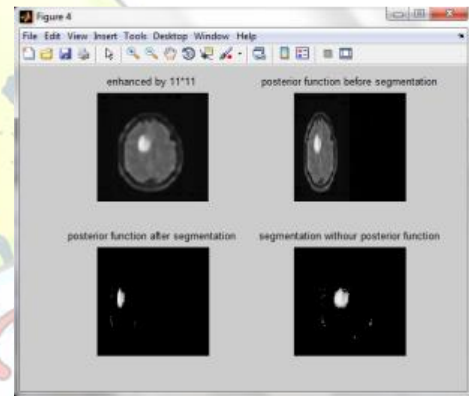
A sample of segmented MRI brain image by ACO algorithm.
